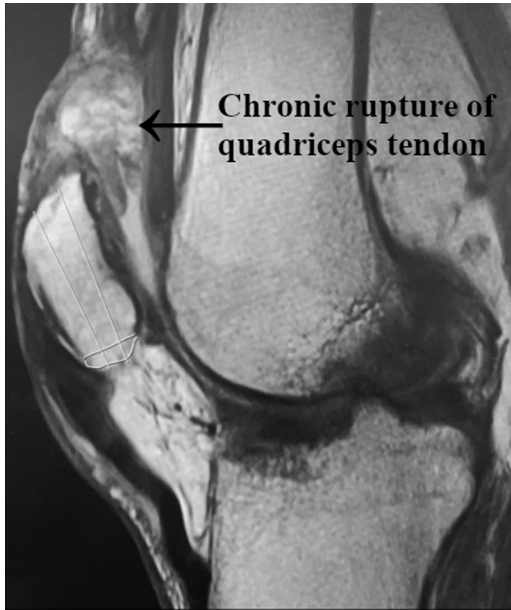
Preoperative T1 sagittal magnetic resonance imaging of the left knee demonstrating a chronic rupture of the quadriceps tendon.
